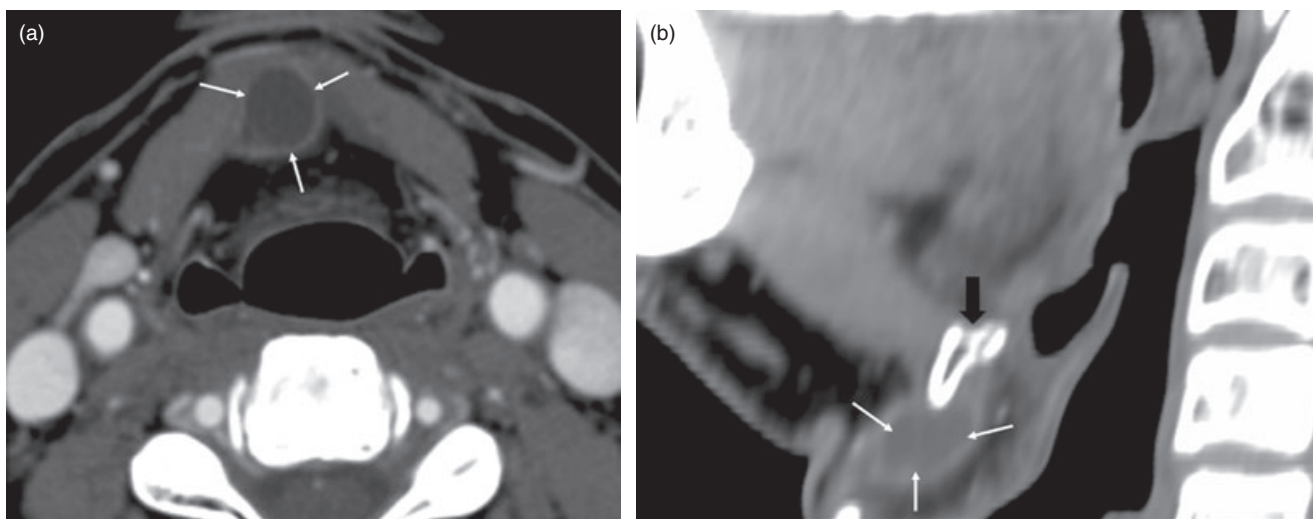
(a) Axial contrast enhanced CT section performed about 18 months later reveals a low-attenuation structure (white arrows) in the pre-epiglottic space with a mildly enhancing rim. (b) Sagittal reformatted CT demonstrates the close proximity of the cystic structure (white arrows) to the hyoid bone (black arrow).
